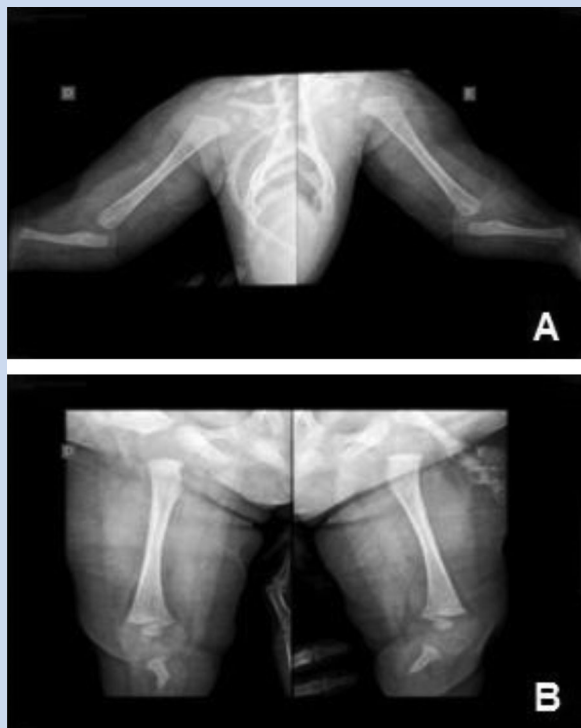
Limb radiographs. A: Upper limbs, normal humerus. B: Lower limbs, normal femora, agenesis of fibulae, and normal pelvis.
